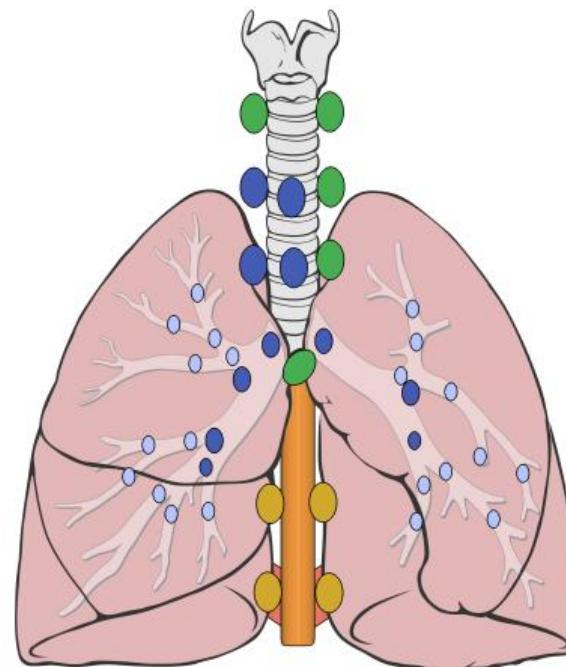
Nodal access of different EUS-guided biopsy platforms. A representative figure summarizing the relatively nodal access of each EUS system. ■, EBUS and EUS accessible; □, primarily EBUS accessible; ▨, primarily thin EBUS accessible; ▨, primarily EUS accessible. EBUS, endobronchial ultrasound; EUS, endoscopic ultrasound. Adapted from original (<http://goo.gl/xuJRCO>) by Patrick J. Lynch and C. Carl Jaffe under Creative Commons Attribution 2.5 License (<https://creativecommons.org/licenses/by/2.5/>).
